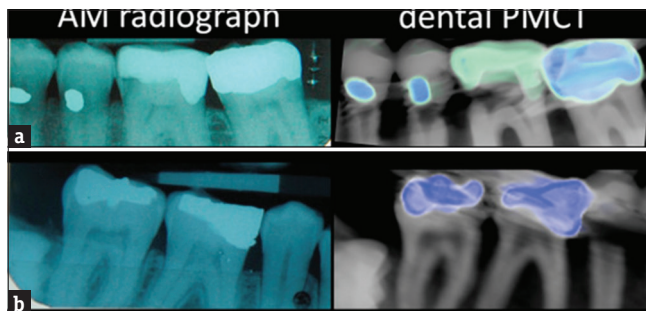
(a and b) both images are comparing between dental antemortem radiograph and dental postmortem CT
